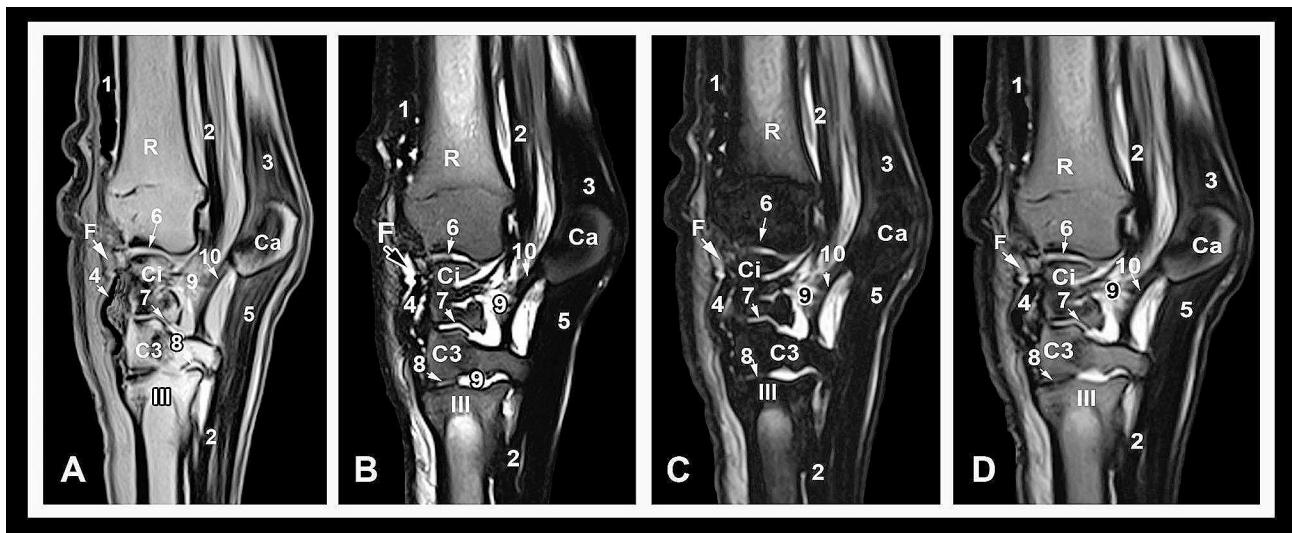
Sagittal T1 (A), T2 (B), STIR (C) and PD-weighted (D) high-field MRI images obtained in the axial aspect of the carpus at the level of the intermediate carpal bone. Dorsal is to the left. R, radius; Ci, intermediate carpal bone; Ca, accessory carpal bone; III, 3rd metacarpal bone; F, fat pad; 1, common digital extensor tendon; 2, deep digital flexor tendon; 3, ulnar carpal flexor tendon; 4, radial carpal extensor tendon; 5, superficial digital flexor tendon; 6, articular cartilage of the antebrachio-carpal joint; 7, articular cartilage of the middle inter-carpal joint; 8, articular cartilage of the carpo-metacarpal joint; 9, synovial fluid; 10, accessory quartal ligament
